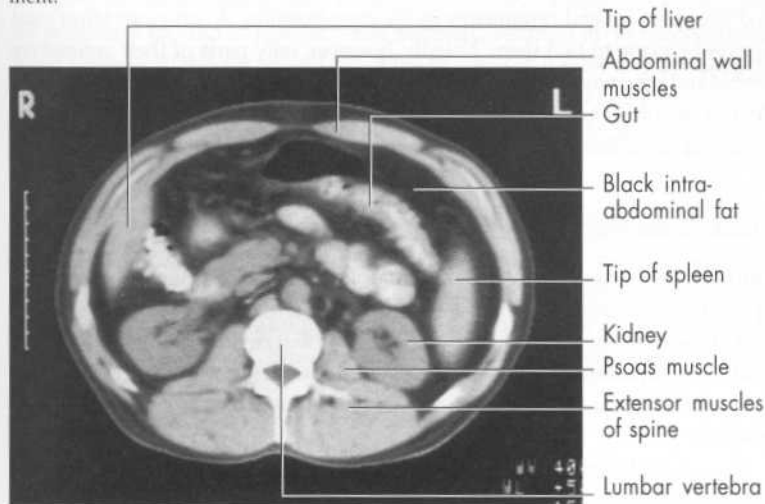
Intra-abdominal fat This is a normal abdominal CT scan at the level of the kidneys.
